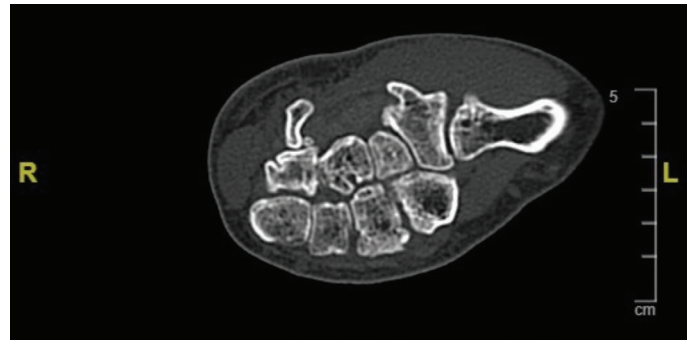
Right dorsal view X-ray showing carpal bones with abnormal anatomical alignment.
